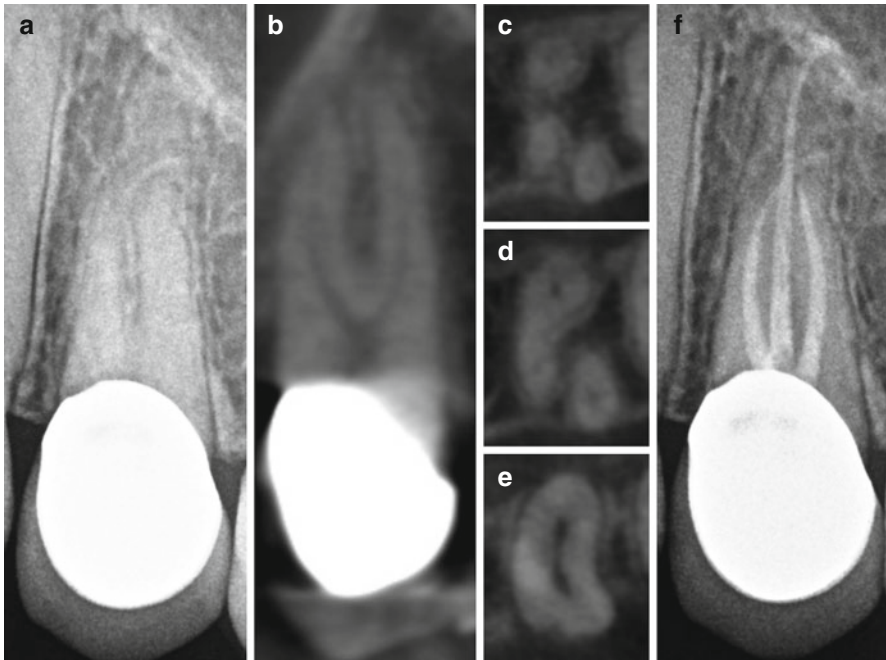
Preoperative periapical radiograph of a maxillary left first premolar (a) with corresponding sagittal CBCT slice demonstrating a canal division of the buccal roots (b). Axial CBCT slices captured from the apical third (c), mid-root (d), and coronal third (e) demonstrate a trifurcation of the root canal system with three separate roots. Post-endodontic periapical radiograph demonstrates all identified root canal systems treated (f)
